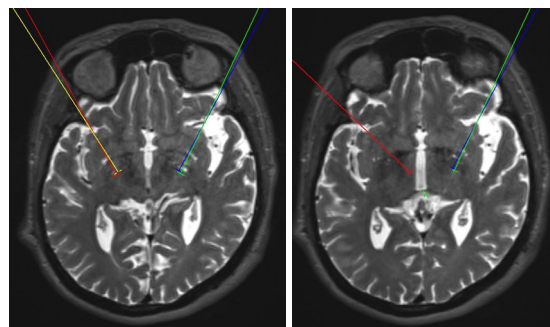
T2W MRI showing targeting of Bilateral GPi. 1b: T2 W MRI showing targeting of right sided PTT and left sided Gpi.
